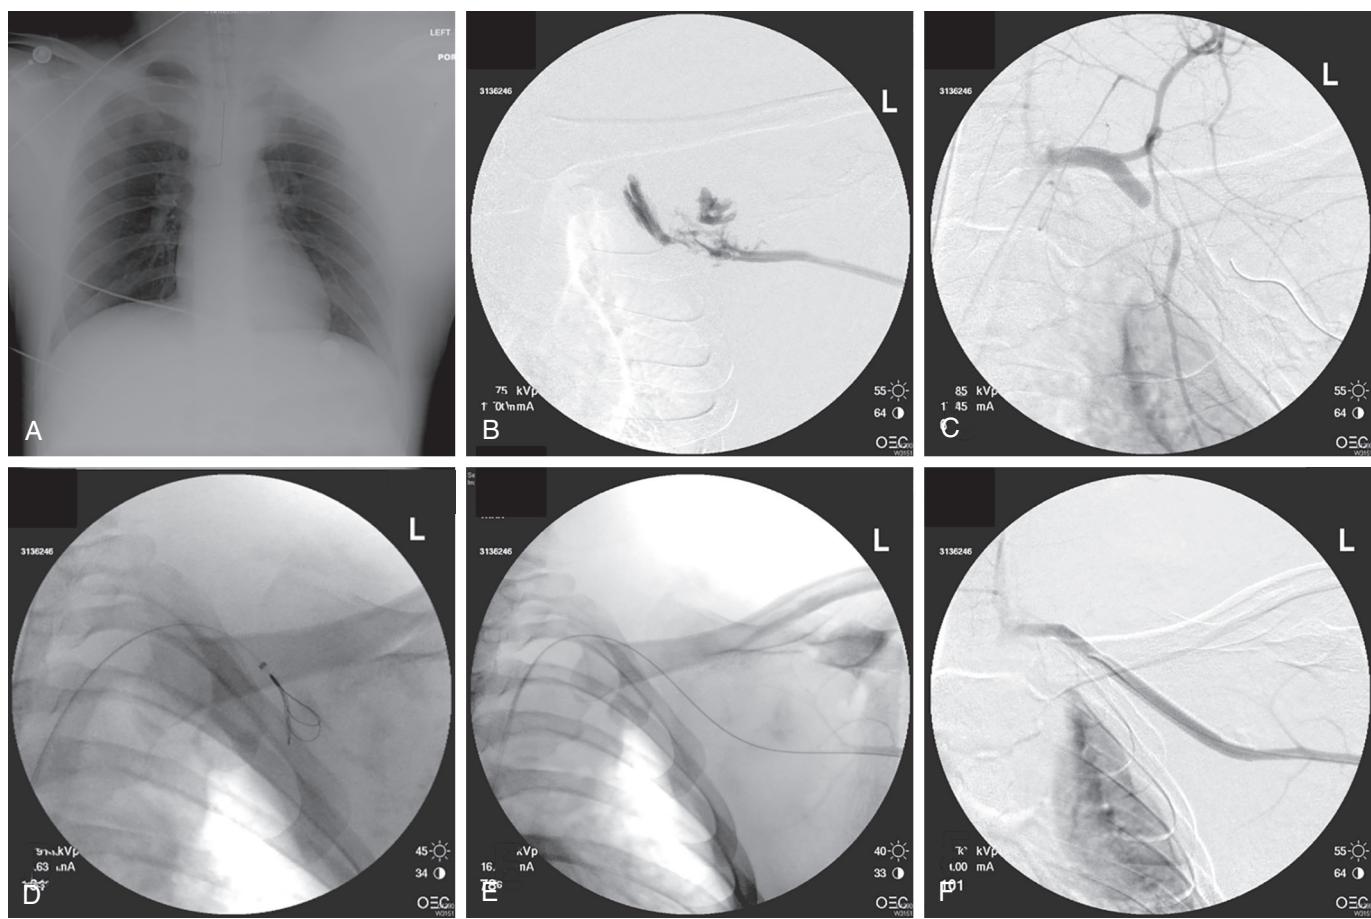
Blunt subclavian artery transection. (A) The patient presented with a large stable hematoma in the suprACLAVICULAR fossa extending into the axilla after a high-speed motorcycle crash. The chest radiograph demonstrates the soft tissue density over the left clavicle. (B) From the left brachial approach, there is extravasation at the level of the subclavian to axillary artery junction. (C) From the right groin, left subclavian artery selective angiography was performed. (D) A curved Glidewire was used to cross the transection. (E) Once the transection was crossed, the brachial wire was snared within the hematoma, obtaining femoral–brachial wire access. The transection was treated with a covered stent. (F) Completion angiogram demonstrates complete exclusion of the transected segment and no residual extravasation.
